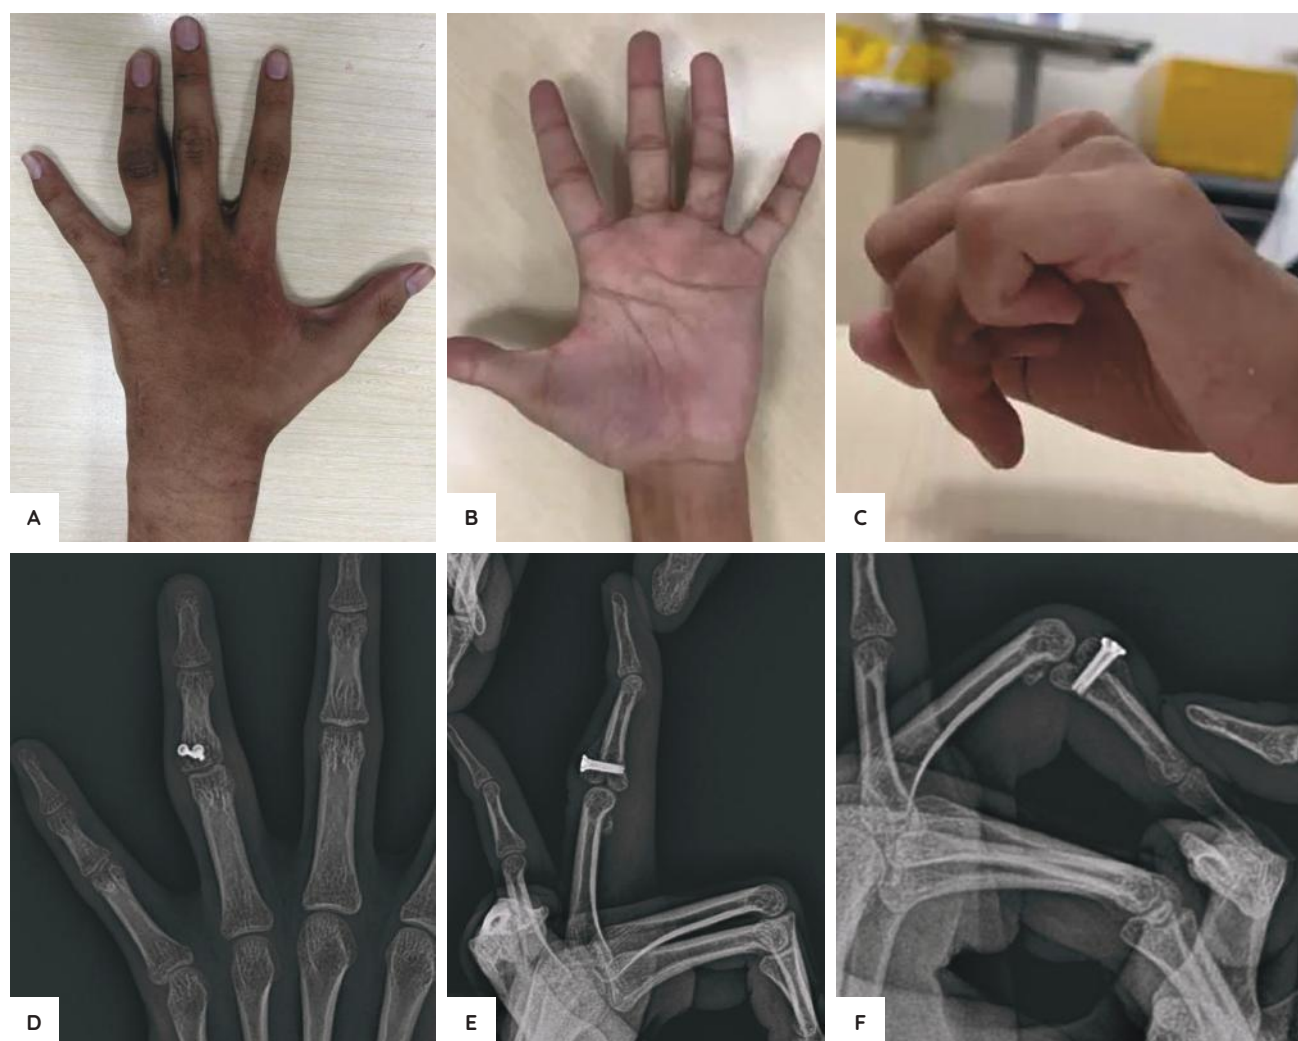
At six weeks postoperatively, wounds were healed. Patient was allowed range of motion as tolerated (A, B, C). X-rays showed partial obliteration of the graft edges, indicating union (D, E, F).
